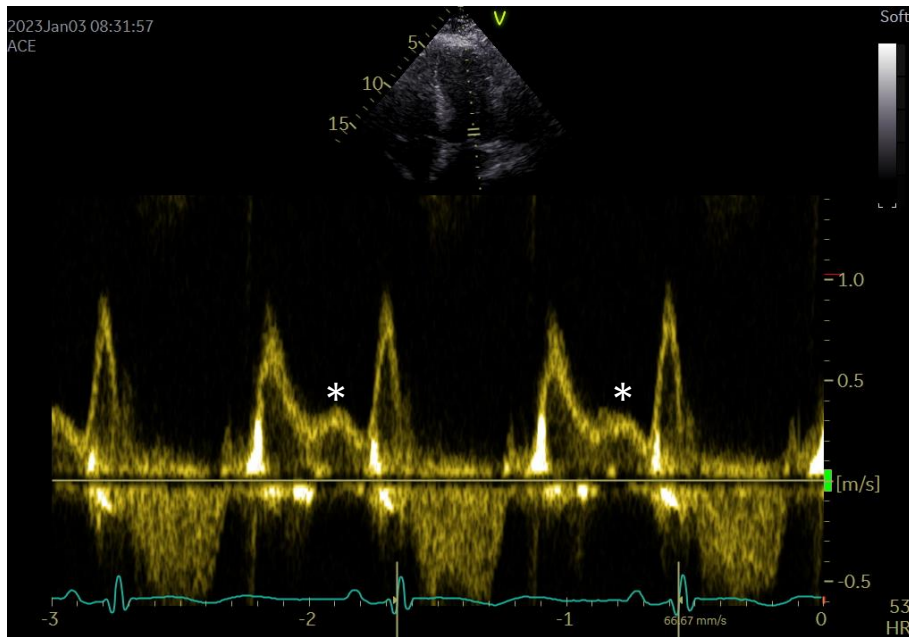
PW Doppler of mitral inflow with prominent L-waves marked with asterisks. The L-waves cannot be analyzed by the PDF method.
